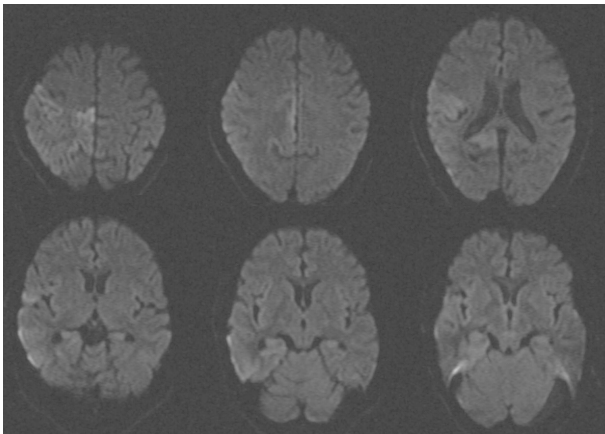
Initial MRI. Diffusion-weighted images show high signal intensities in the sensory motor cortex, without signal changes in the striatum.
